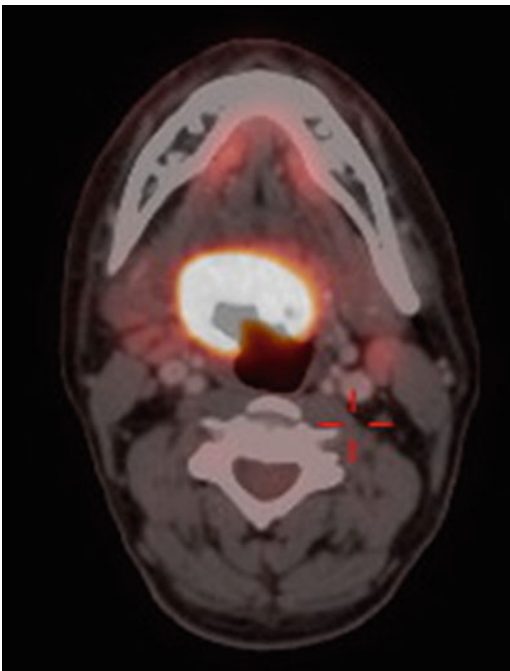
PET/CT fusion axial image showing an enhancing lesion involving the right base of tongue suggestive of neoplastic etiology
